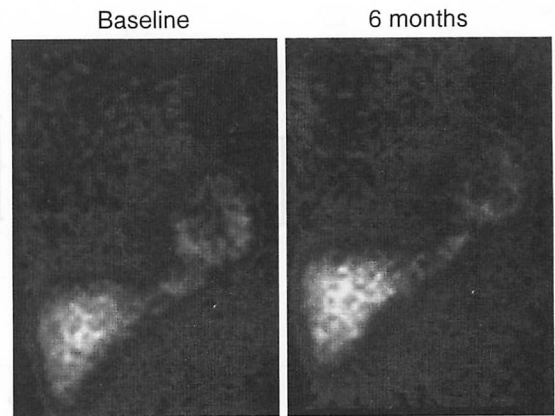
Iodine-123 BMIPP myocardial SPECT planar images before and 6 months after treatment in Responder 2
